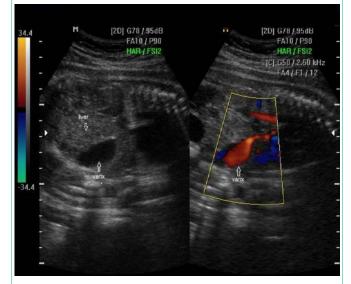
a-b: a) A-Gray-scale ultrasound image showing a fetal intraabdominal intrahepatic umbilical vein varix in a 30-week fetus.
